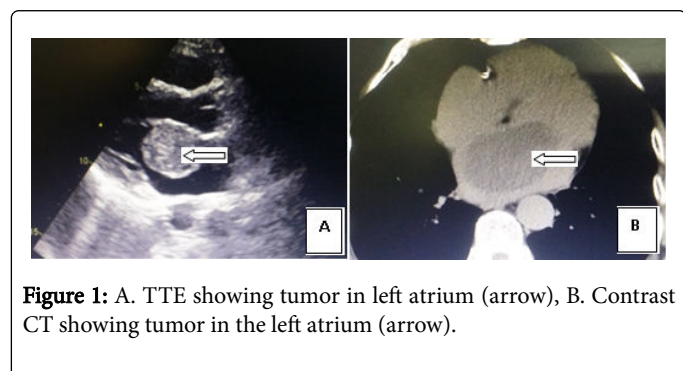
A. TTE showing tumor in left atrium (arrow), B. Contrast CT showing tumor in the left atrium (arrow).
